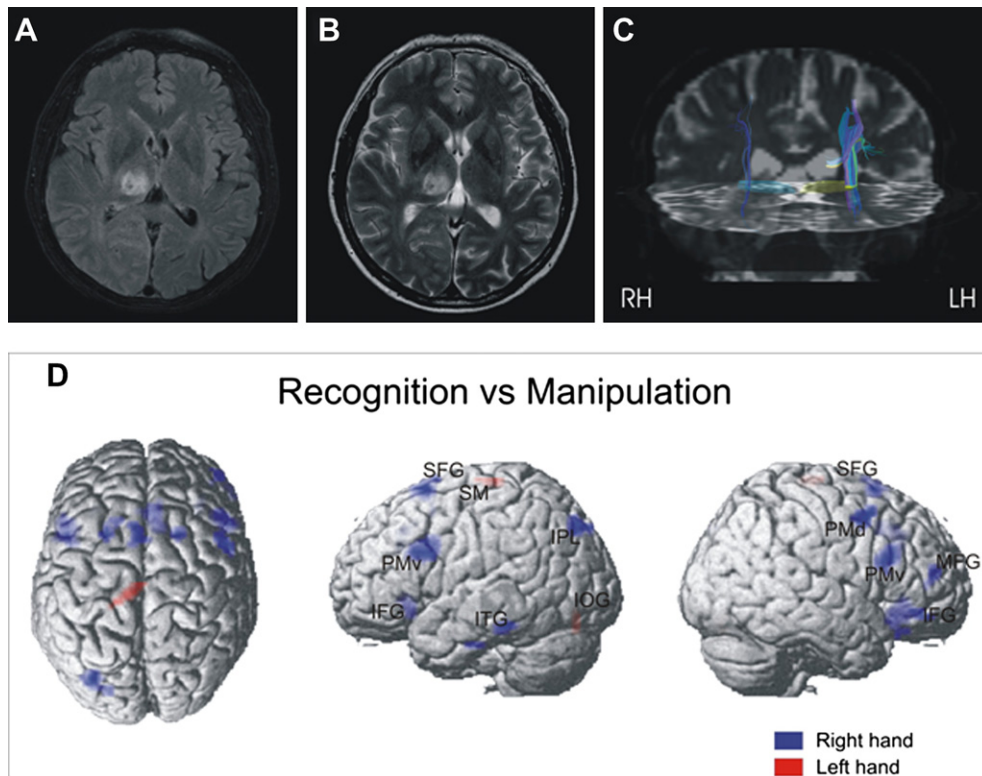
MR imaging, tractography and statistical parametric maps. Axial FLAIR (A) and TSE T2-weighted (B) sequences demonstrating the presence of right thalamus ischemic lesion. Diffusion tensor fiber tracking of the thalamo-cortical sensory pathways (C) demonstrates a reduction of fibers in the right hemisphere (images are displayed according to the radiological convention). Statistical parametric maps (D) showing areas with a significant ($p < .01$ corrected) effect of the recognition respect to the manipulation task. Blue patches represent right hand activation, red patches left hand activation. SFG, superior frontal gyrus; MFG, middle frontal gyrus; IFG, inferior frontal gyrus; PMv, ventral premotor cortex; PMd, dorsal premotor cortex; SM, sensorimotor cortex; IPL, inferior parietal lobule; ITG, inferior temporal gyrus; IOG, inferior occipital gyrus.
